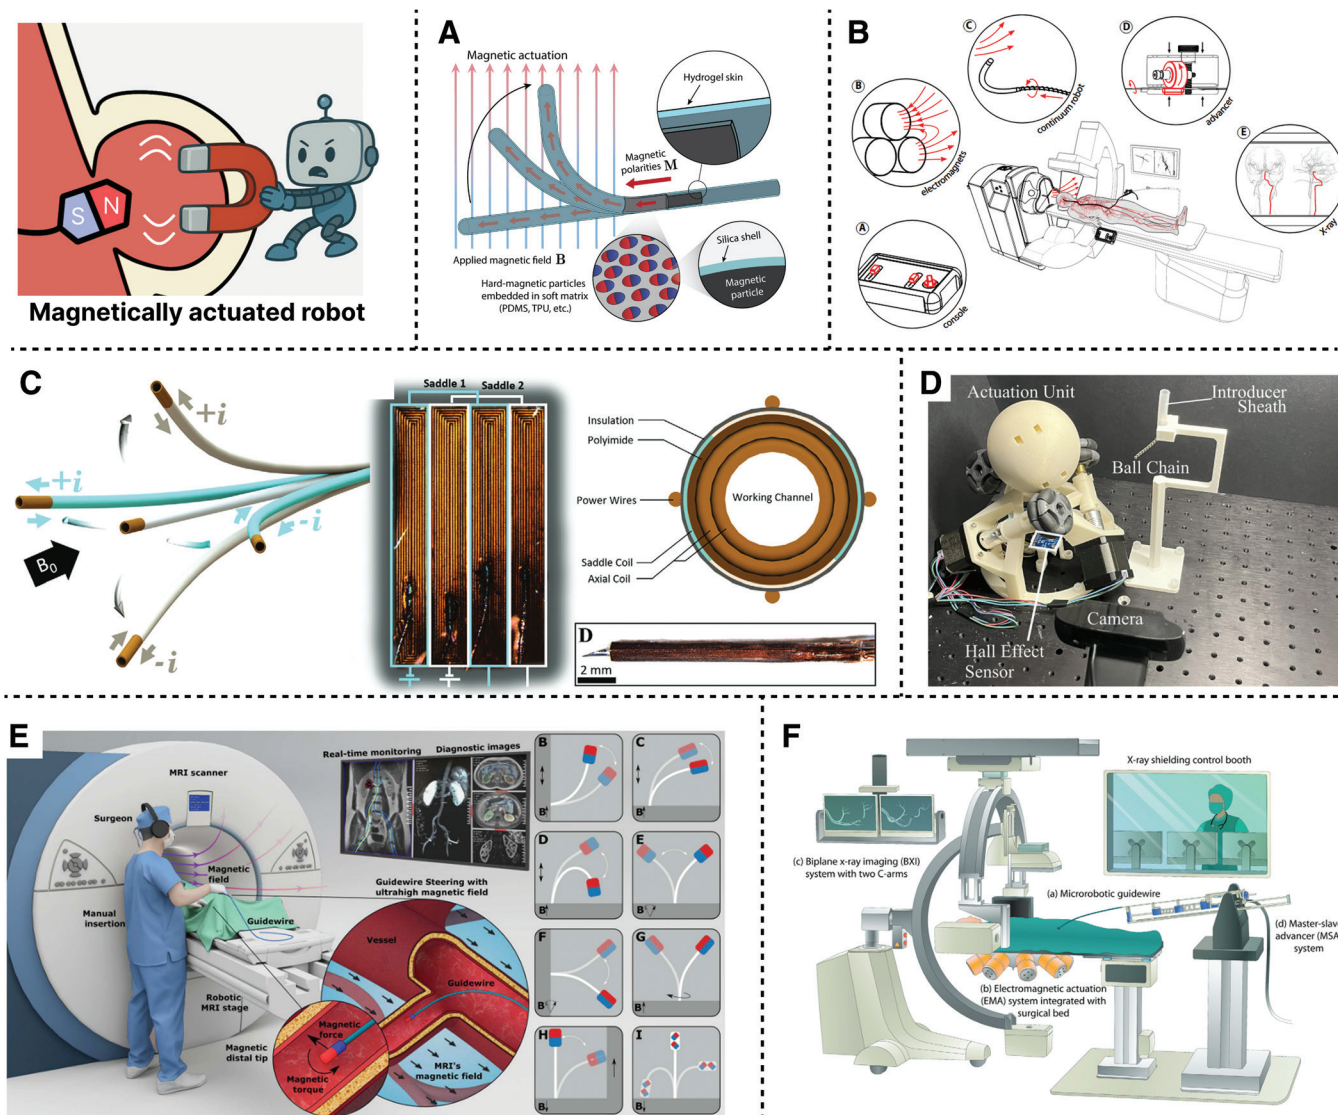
Magnetically actuated robot. (A) Ferromagnetic robot. Reproduced with permission from Kim et al.^[116] Copyright 2019, The American Association for the Advancement of Science. (B) Helical robot with screw like propulsion. Reproduced with permission from Dreyfus et al.^[107] Copyright 2024, The American Association for the Advancement of Science. (C) Lorentz steered the microcoil catheter for MRI guidance. Reproduced with permission from Phelan et al.^[108] Copyright 2022, Wiley-VCH GmbH. (D) Magnetized guidewire enabling in situ steering. Reproduced with permission from Tiriyaki et al.^[109] Copyright 2023, The American Association for the Advancement of Science. (E) Electromagnetic system with micro robotic guidewire. Reproduced with permission from Hwang et al.^[110] Copyright 2022, Wiley-VCH GmbH. (F) Permanent magnet system actuating ball chain catheter. Reproduced with permission from Pittiglio et al.^[111] Copyright 2024, IEEE.
